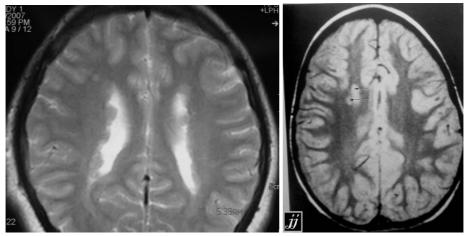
Axial MRI, T1 and T2 show Migration of gray matter into areas of white matter "Ectopic gray matter"
